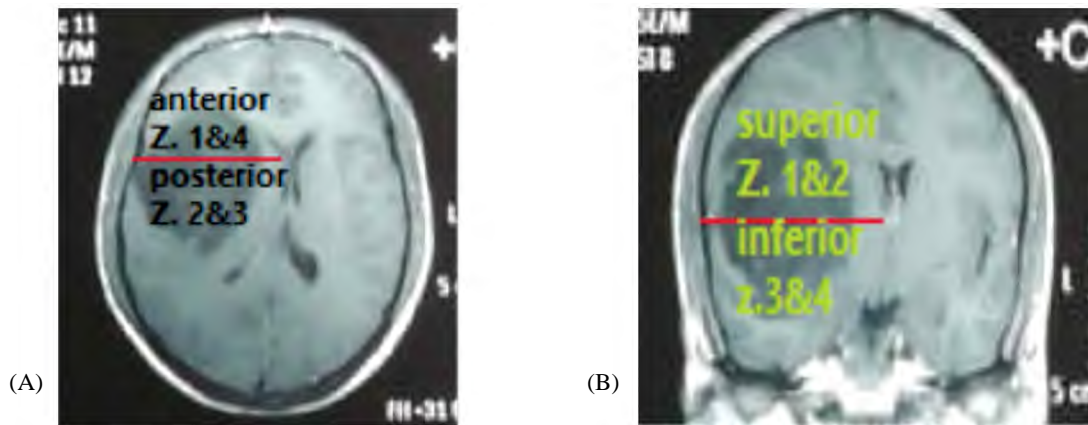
Demonstrate zone classification in MRI and tumor location in relation to different zones. The line passing through the foramen of Monro and the line projected from the sylvian fissure divide the insula into 4 zones. Axial MRI (A) shows the anterior zones (1&4), and coronal MRI (B) showing posterior zones (2&3).
